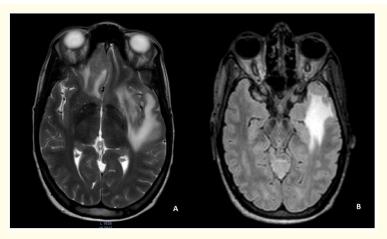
A: MRI in axial section T2WI, B: FLAIR, showed the lesion of the left sylvian valley in high signal intensity T2 and Flair surrounded by a perilesional edema.
